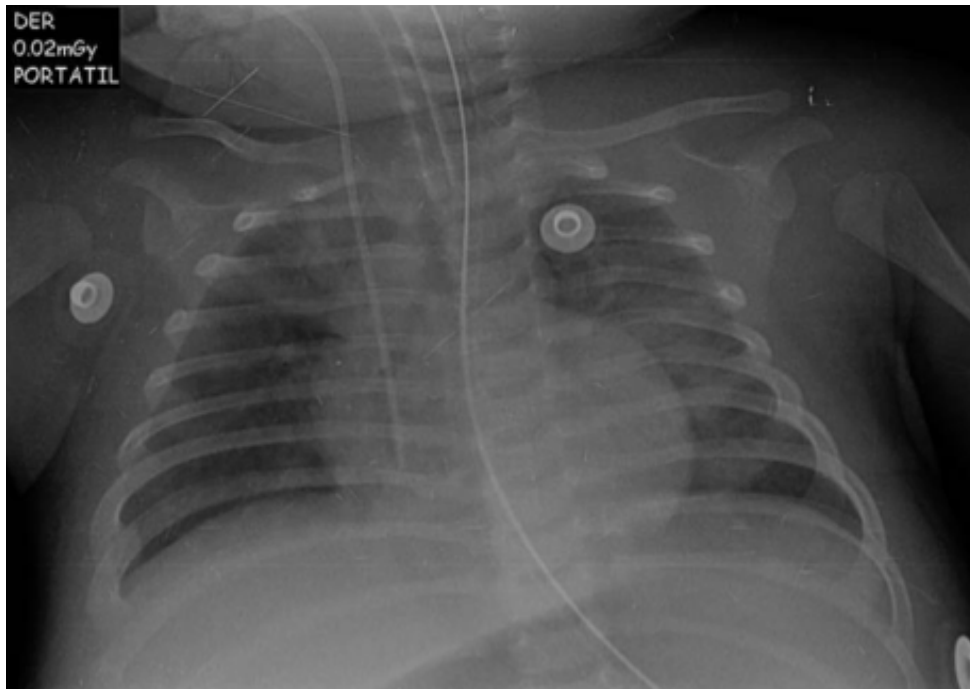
Chest x-ray: improvement in alveolar infiltrates after steroid use (4 days).
